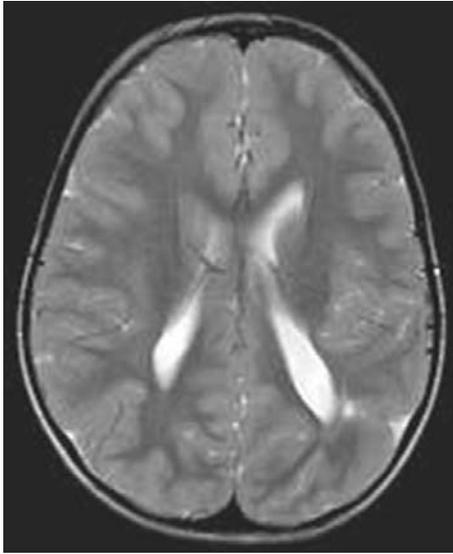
MRI axial T2 weighted shows the cortical-subcortical abnormalities in the left temporo-parietal-occipital region.
